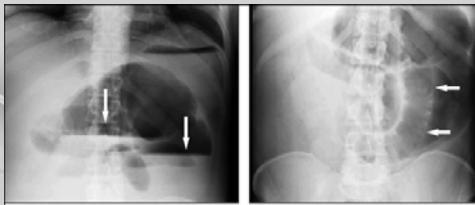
Upright abdominal radiograph showing dilated loops of bowel with air-fluid levels (A; arrows) and a supine abdominal radiograph showing dilated loops of bowel (B; arrows).
